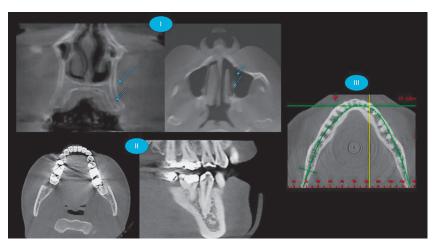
Artifacts. Examples of artifacts found in cone-beam computed tomography (CT) scans: (I) motion artifact (arrows indicate duplication of structures); (II) artifact of dense material, and (III) ring artifact.
